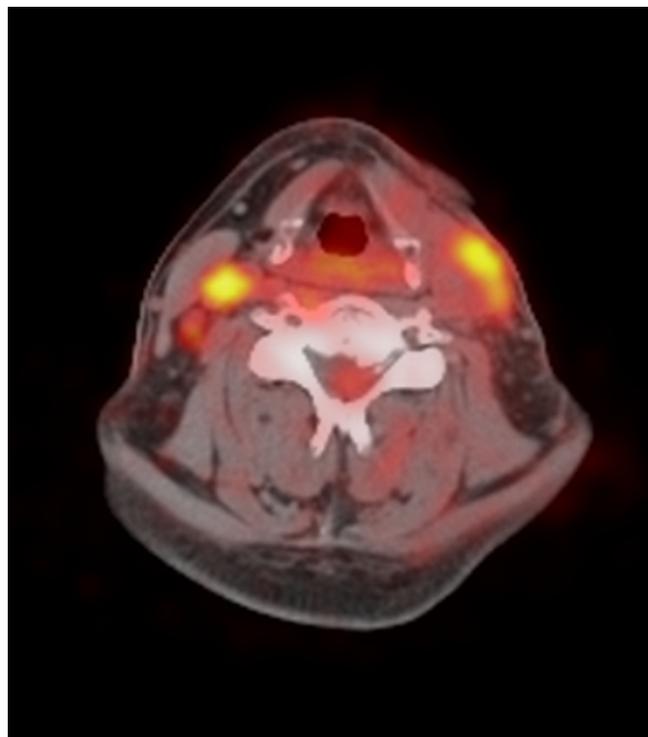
Two weeks post-radiotherapy in patient 11, transaxial ¹⁸F-FDG PET/CT images demonstrate the apparition of a right jugular adenopathy; on the left side, a muscular FDG uptake is well characterized thanks to the PET/CT fusion.
